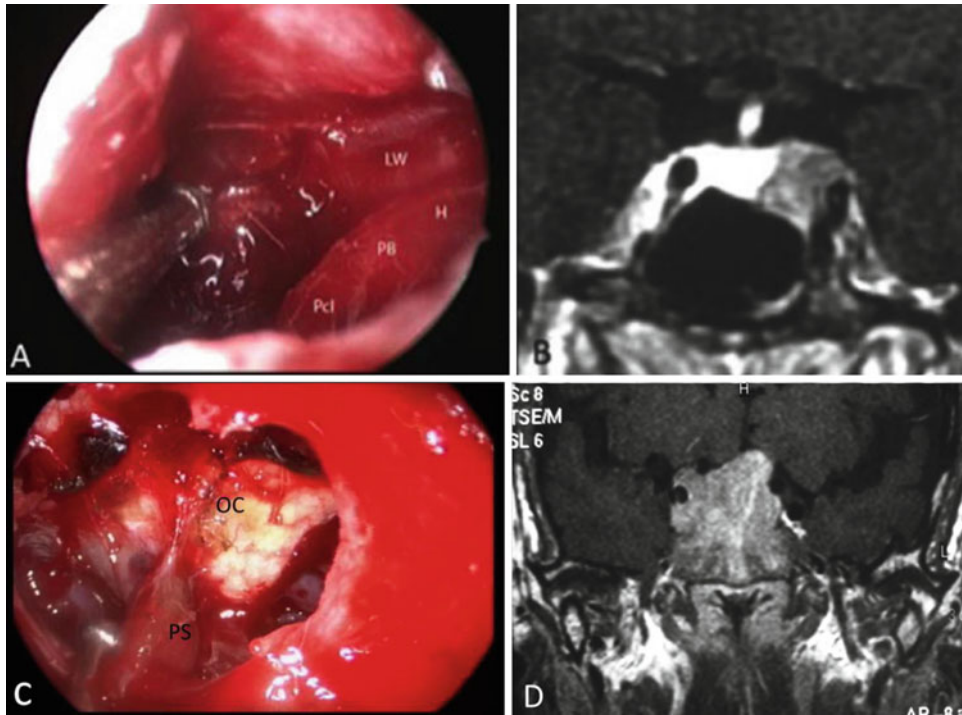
(a, b) 18 year-old female with GH secreting adenoma. (a) Visualization of intracavernous ICA segments. Preoperative (b) Gd-enhanced, T1-weighted MR images of the patient. *LC* lateral corridor, *H* horizontal segment of the cavernous carotid artery, *Pb*
